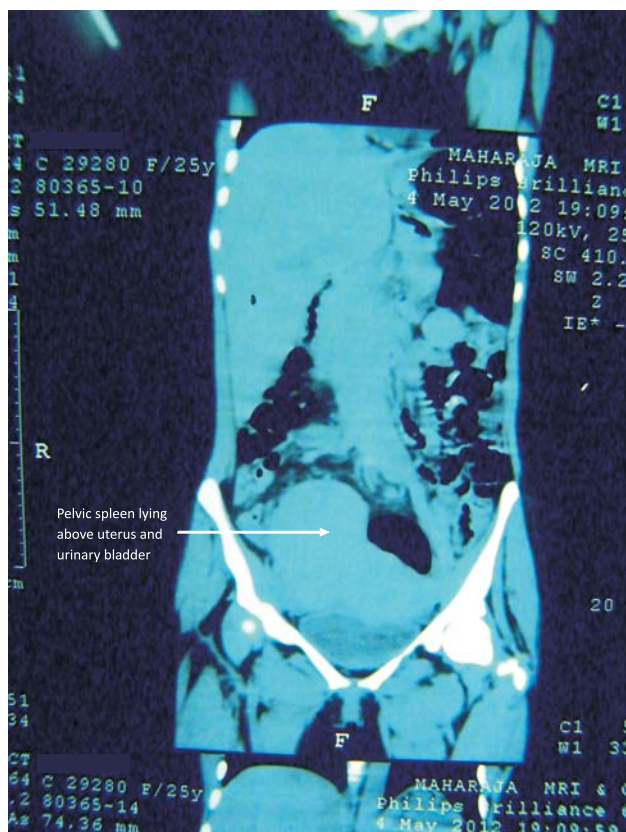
CT abdomen showing pelvic spleen lying above uterus and urinary bladder.
